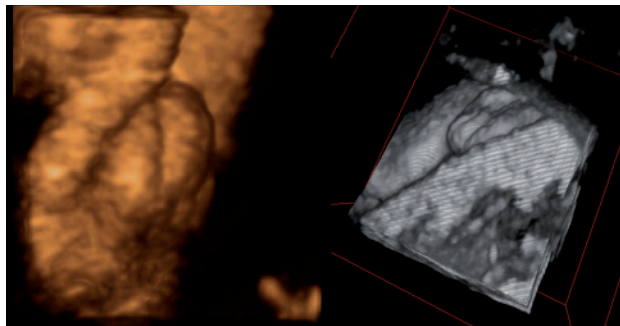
(a) Three dimensional (3D) ultrasound surface-rendered image of the genital area of Patient 3. The skin creases were interpreted as labia majora and the clitoris was thought to be enlarged. (b) I-Space image in which the labia minora are quite obvious.
